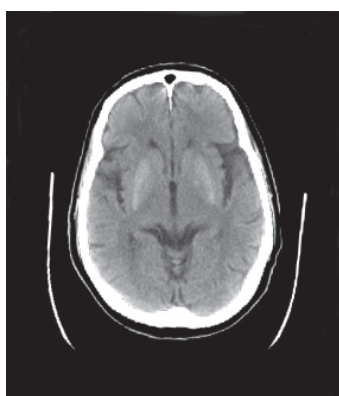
CT Brain showing bilateral basal ganglia hyper-densities (Patient 4)
